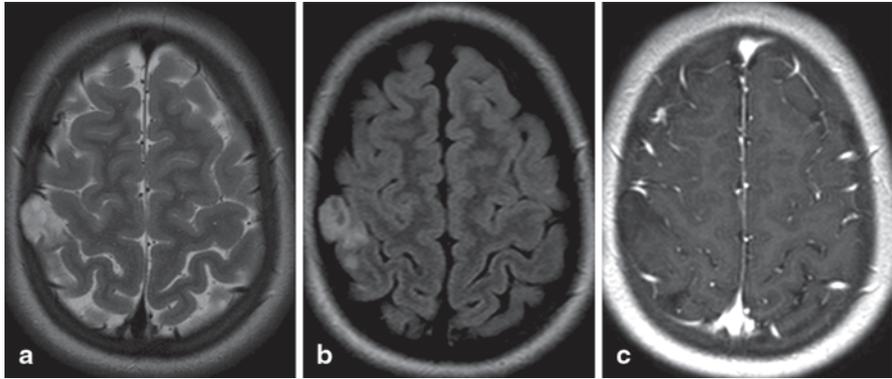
DNT in a 9-year-old girl. a Axial T2-weighted image. b Axial FLAIR image. c Axial Gd-enhanced T1-weighted image. Superficially located tumor involving the right postcentral gyrus with remodeling of the adjacent calvarium (a). Two small internal pseudocysts are visible on FLAIR image (b). There is no enhancement on post contrast T1-weighted image (c)
